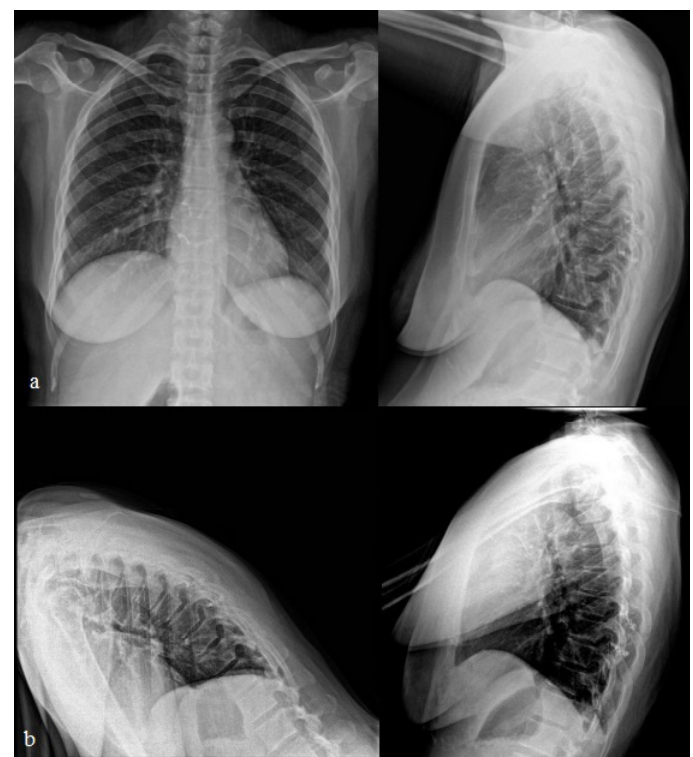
a) Postoperative 2-years anteroposterior and lateral radiographs of the same patient. b) Postoperative 2-years hyperflexion and hyperextension radiographs showing no kyphosis or instability
